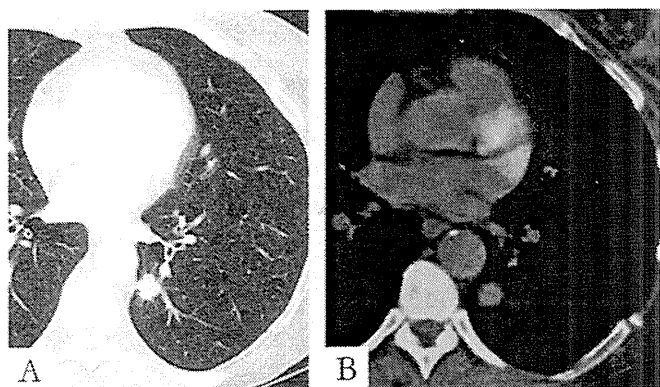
CT and FDG-PET of invasive adenocarcinoma. A, Axial CT image and (B) FDG-PET images show a 2-cm spiculated hypermetabolic solid nodule in the left lower lobe. CT, computed tomography; FDG-PET, fluorodeoxyglucose positron emission tomography.
